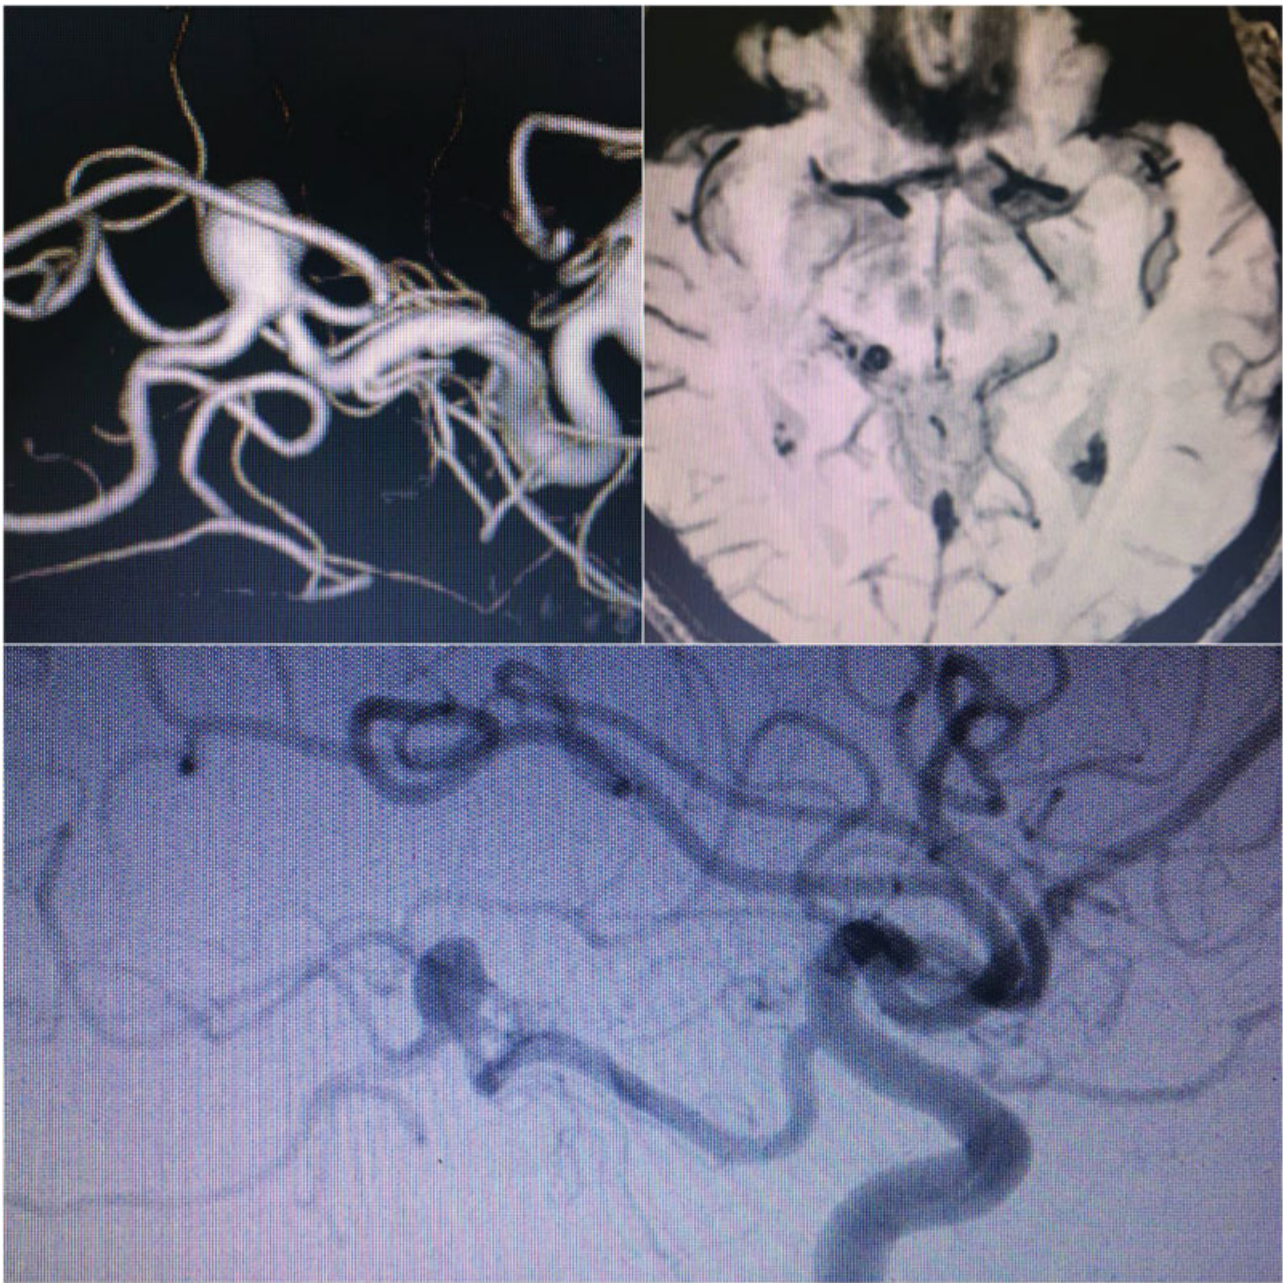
Digital subtraction arteriography (2D and 3D) and magnetic resonance imaging revealing a saccular formation located just posterior to the most lateral portion of the right cerebral peduncle.
